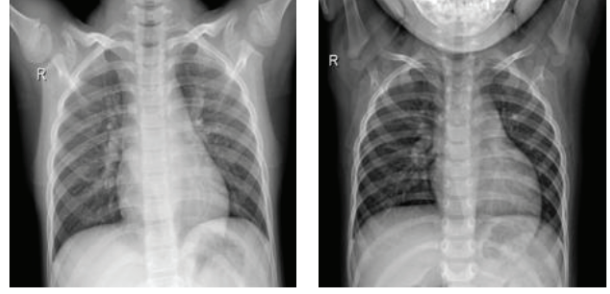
Representative normal chest X-ray images.
